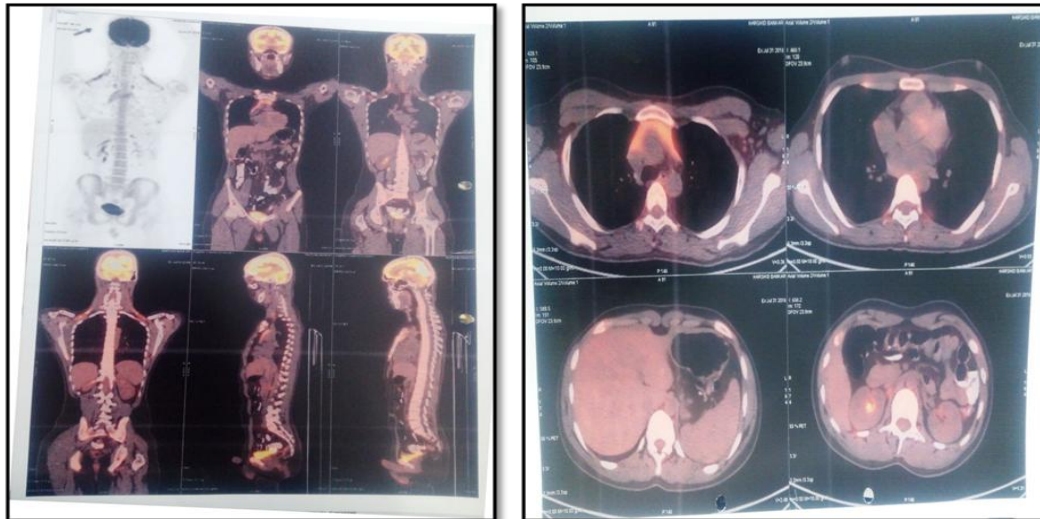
Post-operative PET-CT scan showing no metabolically active disease
